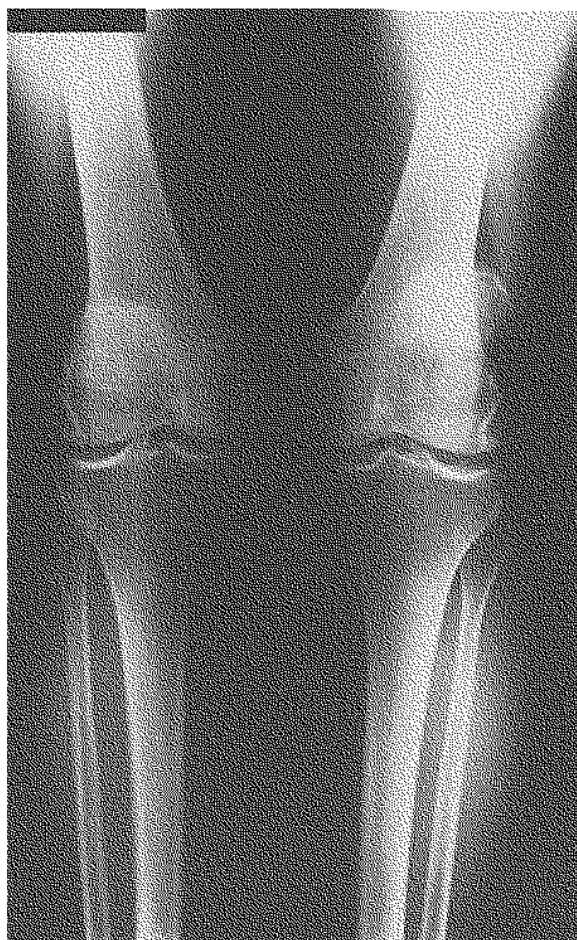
Anteroposterior radiograph of both knees (standing film).
